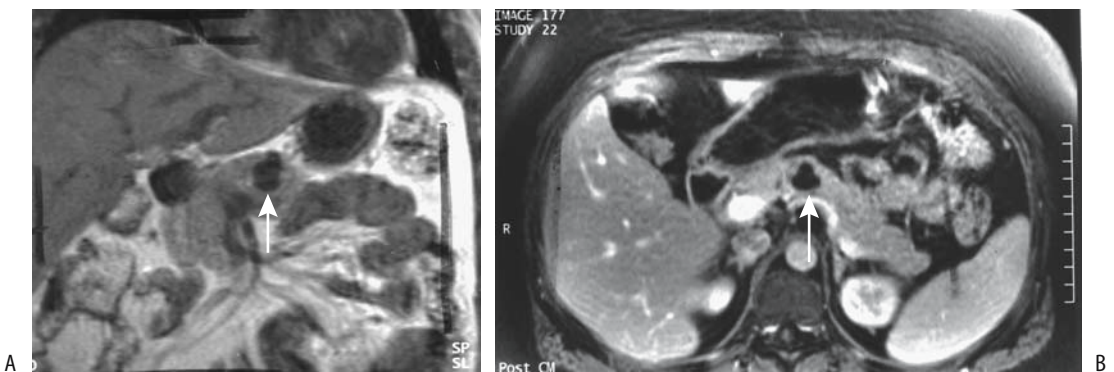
Microcystic adenoma. A: Coronal T1-weighted MR image reveals a pancreatic cyst (arrows). B: It does not enhance after contrast (arrow). (Source: From Burgener FA, Meyers SP, Tan RK, Zaunbauer W. *Differential Diagnosis in Magnetic Resonance Imaging*. Stuttgart: Thieme, 2002, with permission.)
